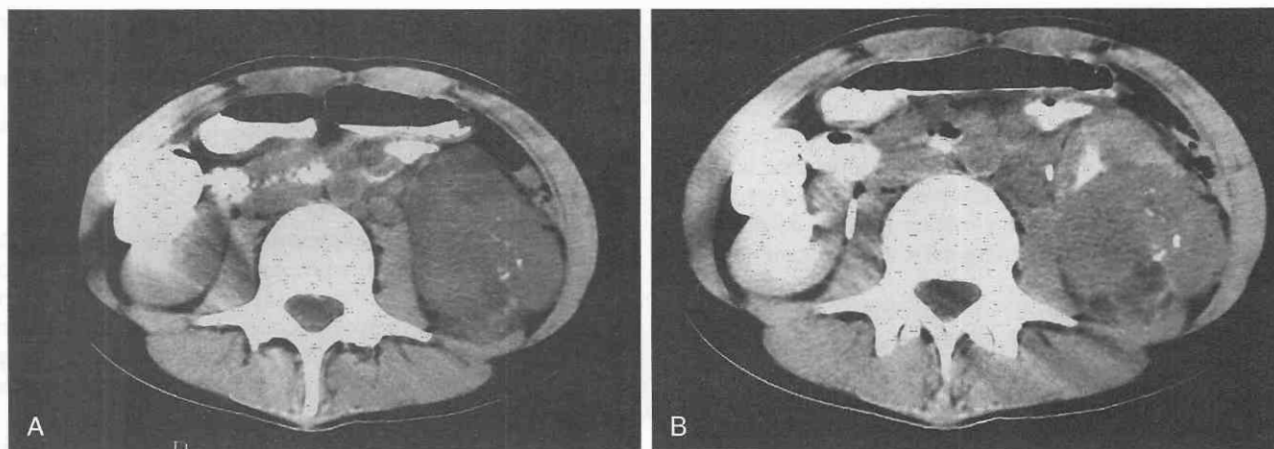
Renal cell carcinoma of the left kidney in a 13-year-old girl. *A*, Nonenhanced CT axial image through the kidneys. A 6-cm solid mass arises from the lower pole of the left kidney. Numerous punctate and stippled calcifications are visible within the mass. *B*, Contrast-enhanced CT axial image through the kidneys. The mass in the lower pole of the left kidney is better demarcated from adjacent uninvolved renal parenchyma after contrast administration. The multiple small calcifications within the mass are again visible.
